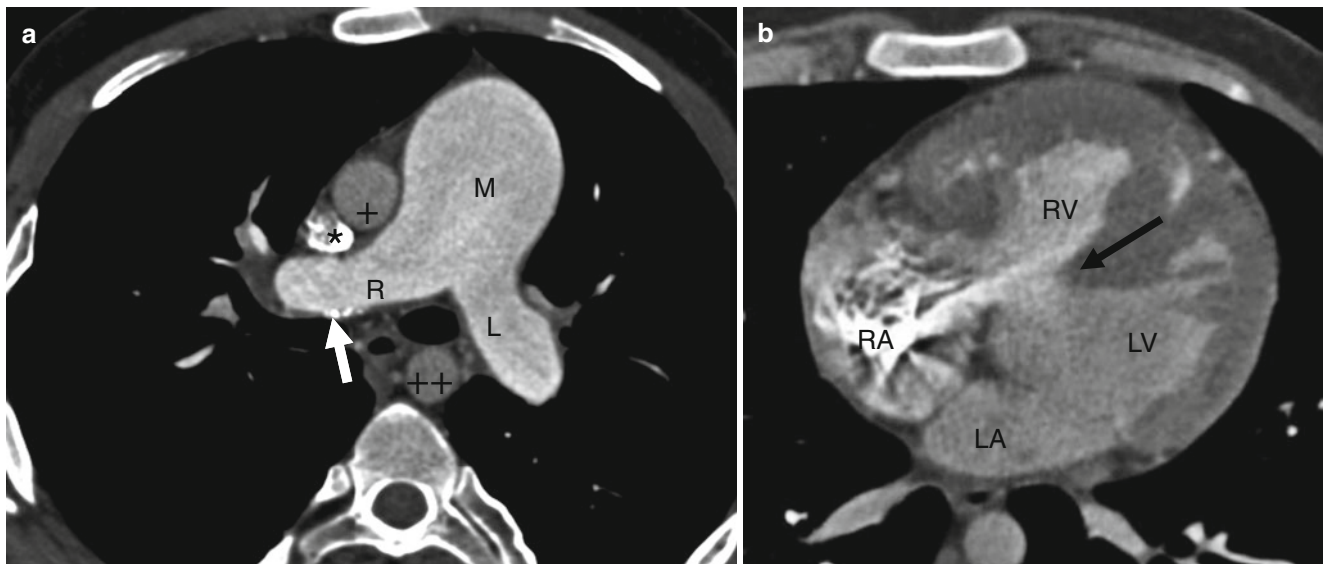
Pulmonary hypertension (Eisenmenger syndrome) due to unrepaired VSD. Panel (a) an axial computed tomogram showing a marked enlargement of the main (M) and proximal right (R) and left (L) pulmonary arteries indicating pulmonary arterial hypertension. Calcification is noted in the right pulmonary artery (white arrow). Panel
